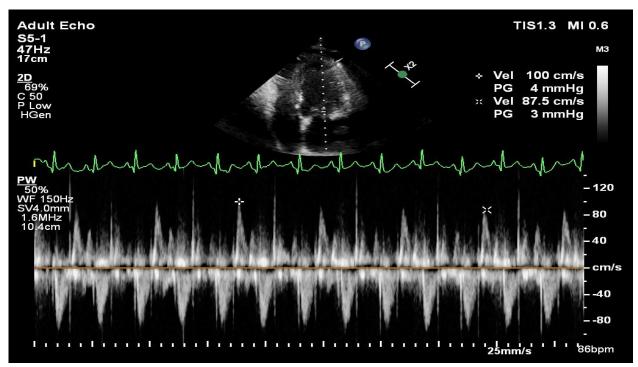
Echocardiogram post pericardiectomy showing no significant respiratory variation in mitral inflow velocity
